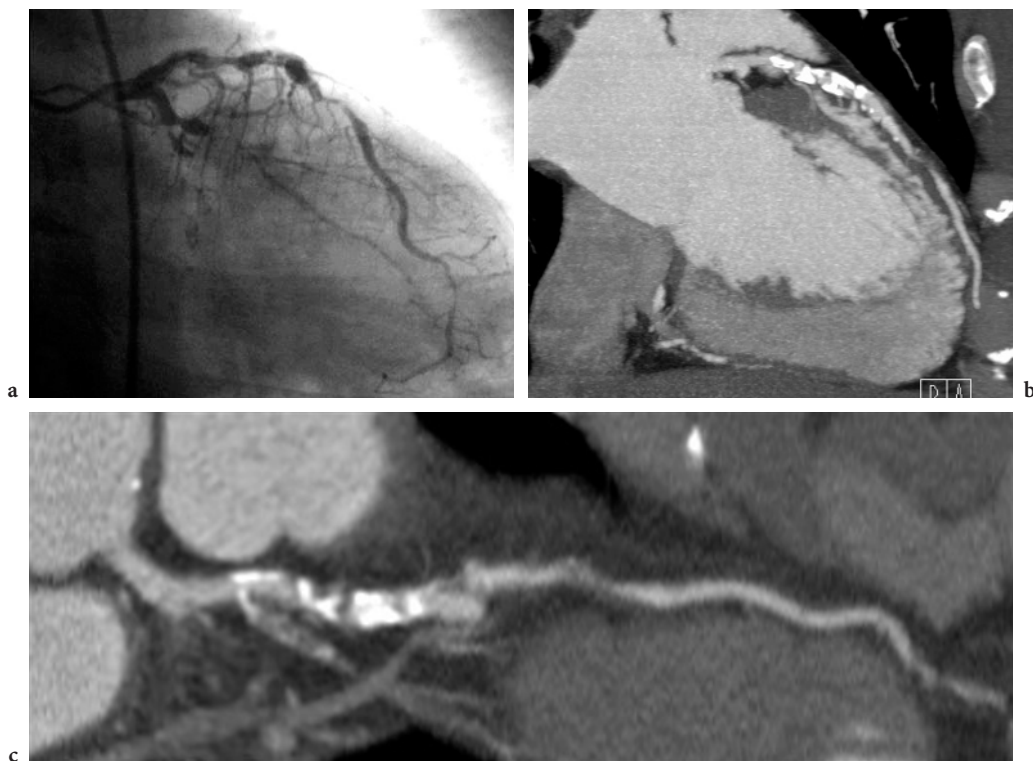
64-slice CT examination of coronary aneurysms in the LAD. Conventional angiography demonstrates an abnormal course of the vessel (a) but does not allow visualization of the atherosclerotic changes. MPR along the long axis (b) and curved MPR (c) reveal the complex atherosclerotic lesions. (Case courtesy of Healthscan, Kuala Lumpur, Malaysia)
